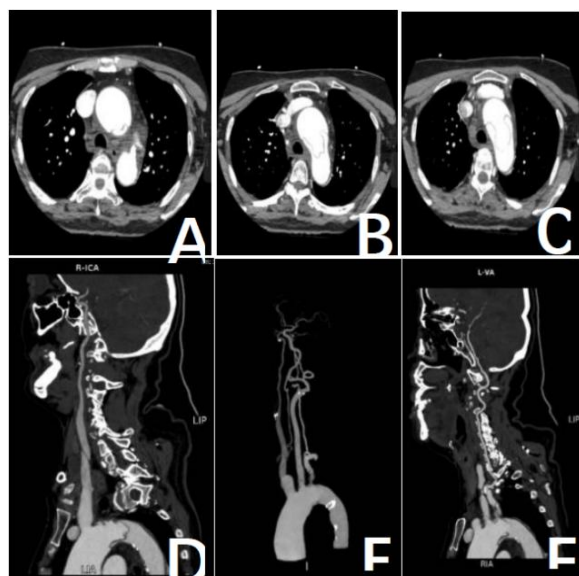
Cranio-Cervical and Thoracic Aorta CTA A - C (Cross-section) D (Sagittal Plane): Stratification of the Lumina of the Ascending Aorta and Aortic Arch. E, F: The Brachiocephalic Trunk Originates from the True Lumen, with the Left Common Carotid Artery and the left Subclavian Artery Straddling the True and False Lumens, and Severe Stenosis at the Proximal End of the Left Subclavian Artery.
